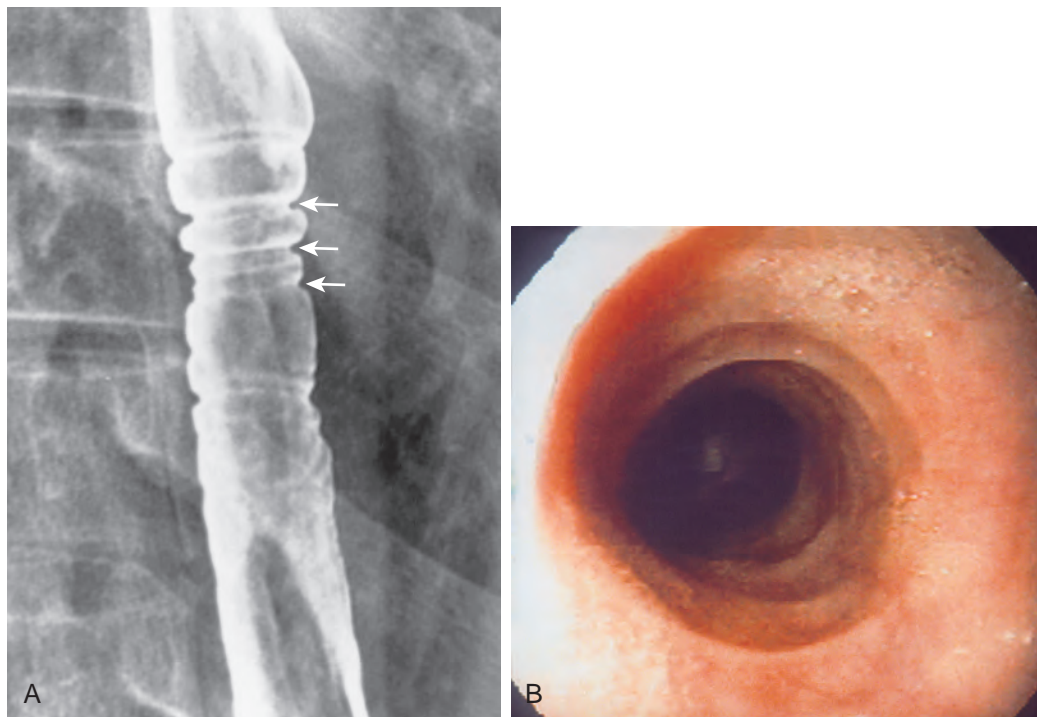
Congenital esophageal stenosis. A. There is a mild area of narrowing in the midesophagus with distinctive ringlike indentations (arrows) in the region of the stricture. B. Endoscopy also shows ringlike indentations that resemble tracheal rings. (A from Luedtke P, Levine MS, Rubesin SE, et al: Radiologic diagnosis of benign esophageal strictures: A pattern approach. *RadioGraphics* 23:897–909, 2003.)
